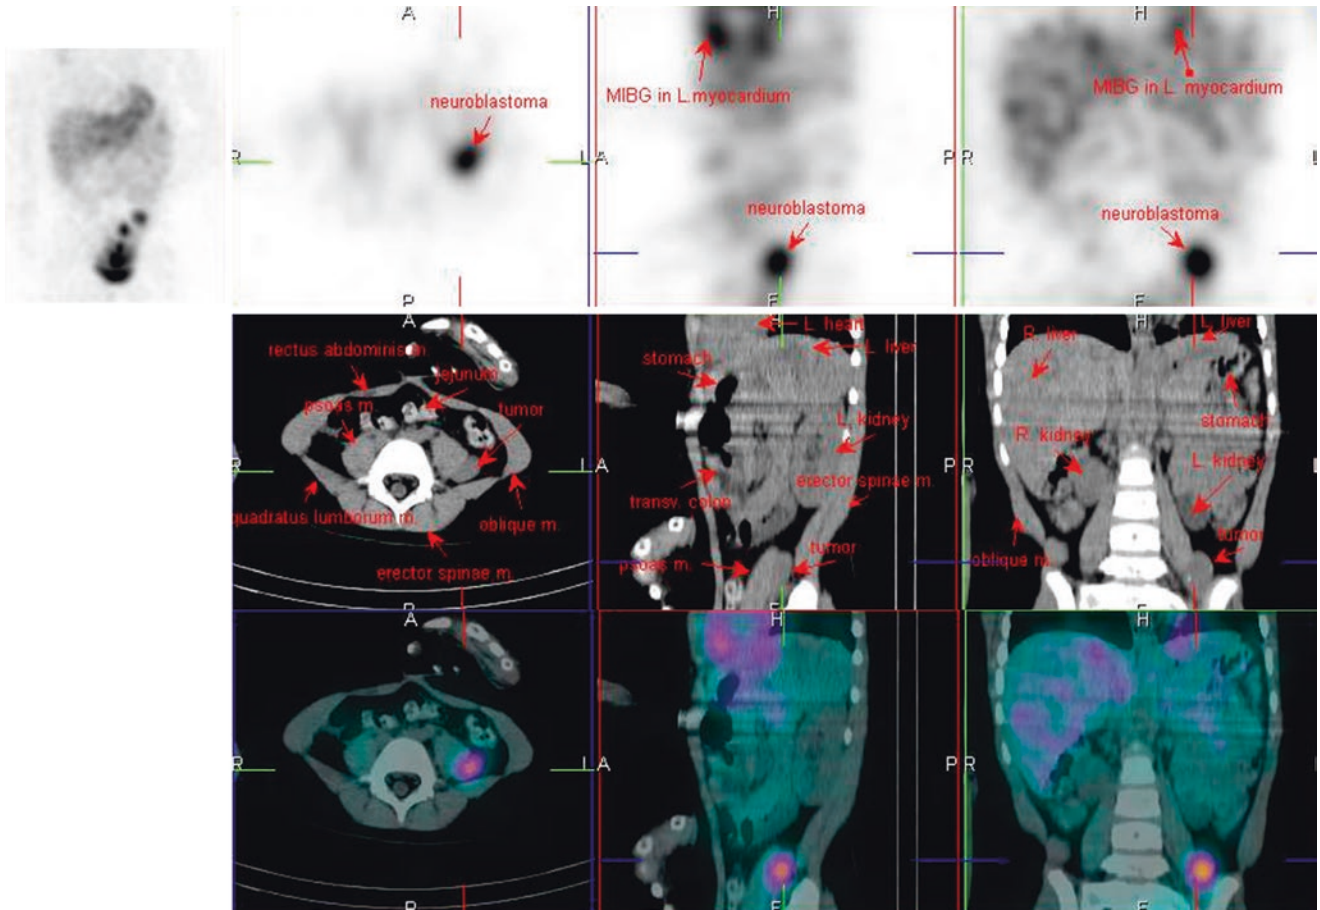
¹²³I-MIBG SPECT/CT
